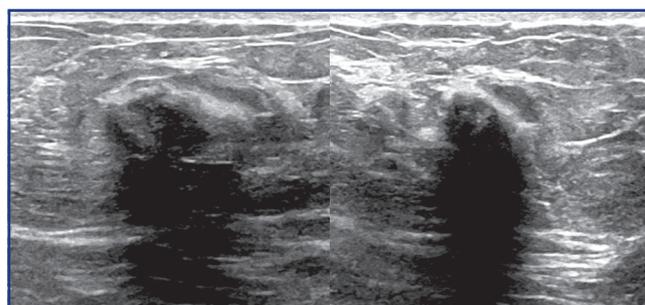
Ultrasound examination of the right mammary gland. A hypoechoic mass with a fuzzy contour and heterogeneous structure.
